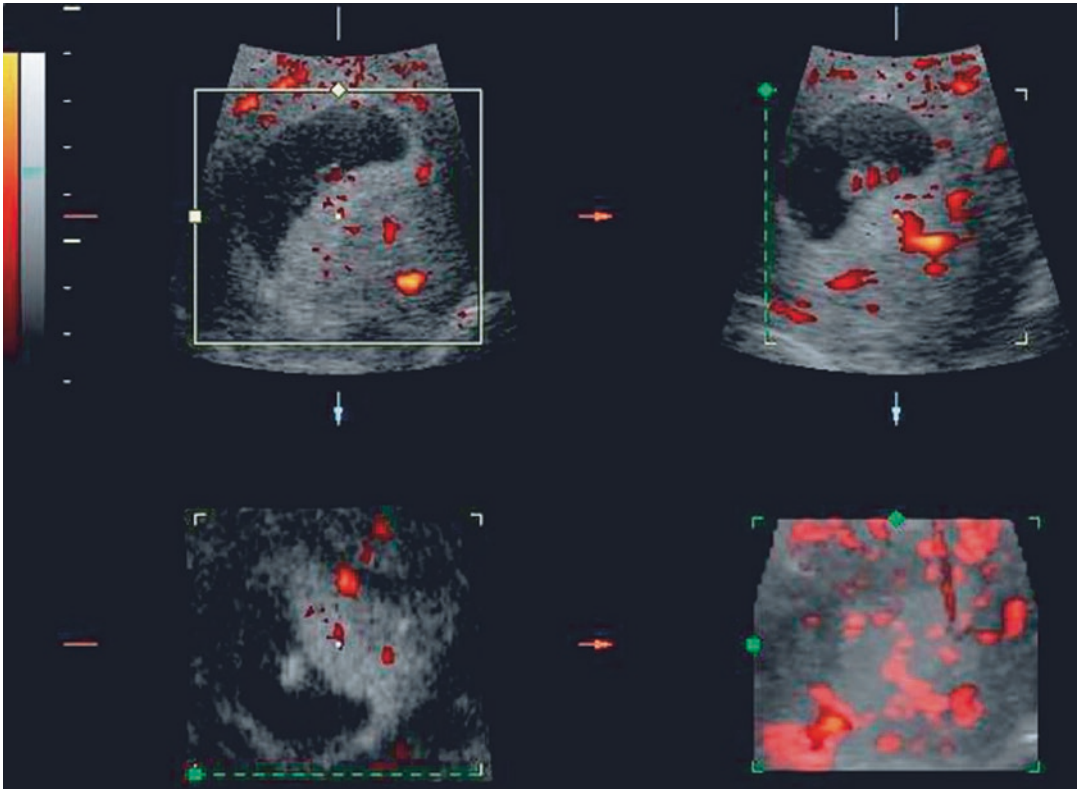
The spatial relationships between the vascular structures of ectopic pregnancy and Fallopian tubes as studied by 3D Doppler ultrasound
